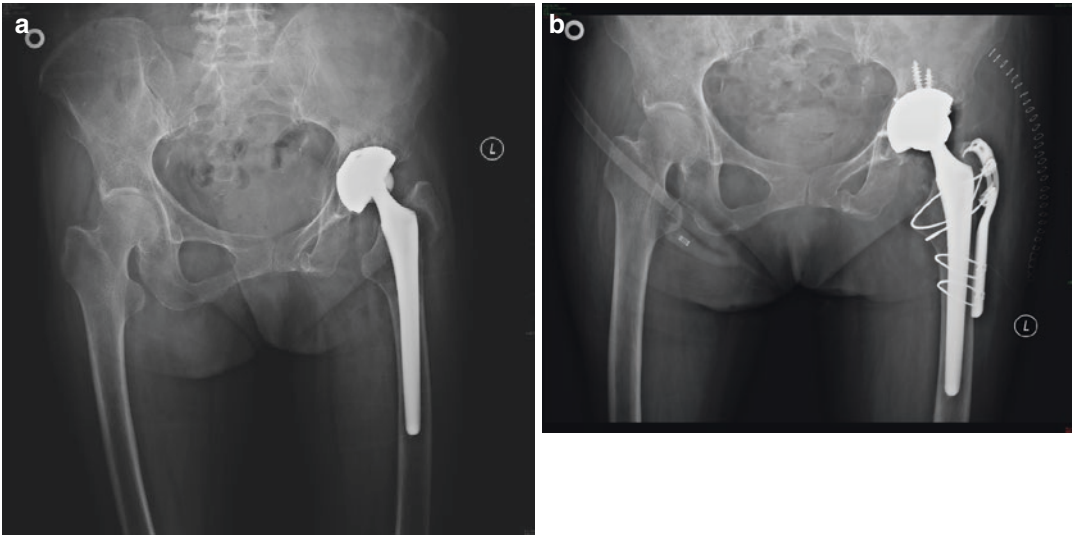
Radiograph of a periprosthetic femoral fracture type A1. (a) Preoperative image. (b) Postoperative image after treatment with a trochanter claw plate
